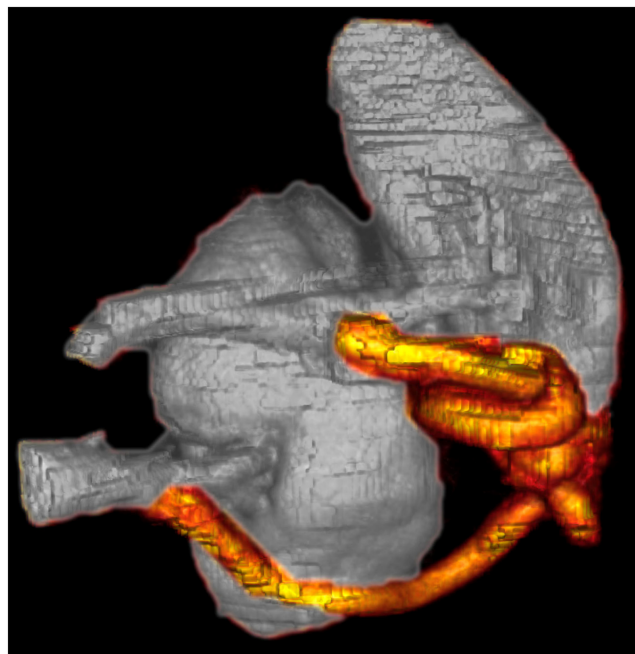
Three-dimensional reconstruction of the abdominal computed tomography on admission, revealing a splenorenal shunt between the left renal vein and splenic vein
